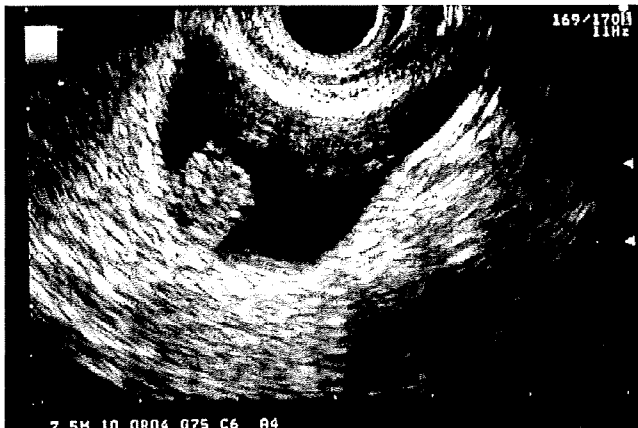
Ultrasound image of adenoma of the gallbladder: this image indicates a semipedunculate polyp with isoechoic signal
